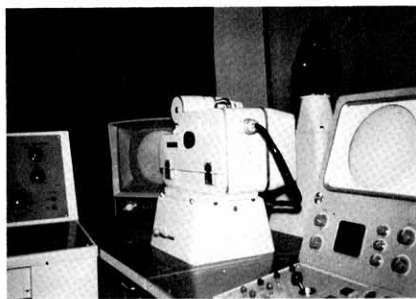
Photograph of a 70 mm. automatic serial roentgenographic camera for telefluororotgenography and a 16 mm. cinecamera for telecine-roentgenography.
